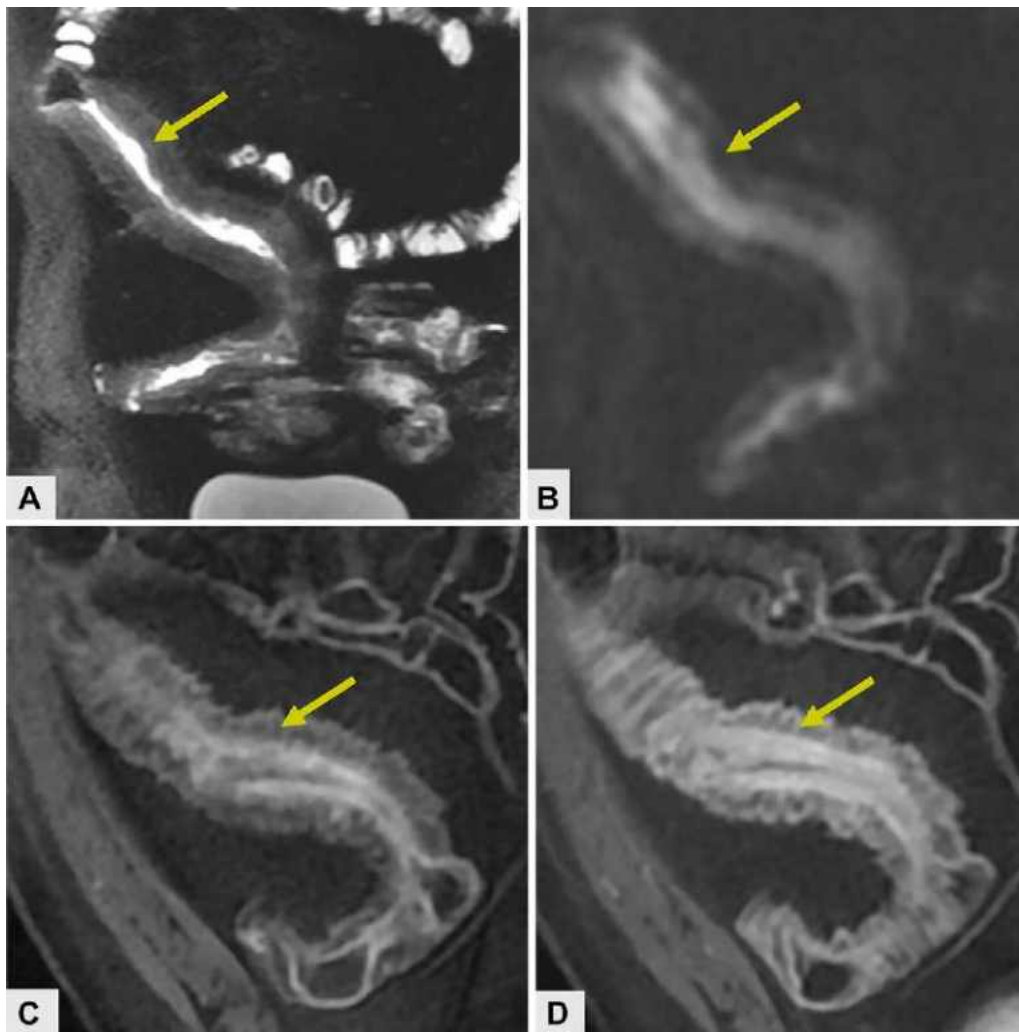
CD stricture with inflammation in a 32-year-old man. (A) Coronal T2-weighted single-shot fast spin-echo fat-saturated MRE image shows ileal luminal narrowing (arrow) with mild-to-moderate intramural edema. (B) Coronal diffusion-weighted MRE image shows restricted diffusion along the inner wall of the stricture (arrow). (C, D) Coronal contrast-enhanced fast spoiled gradient-echo fat-saturated MRE images show a layered pattern of intramural enhancement at 70 seconds (C) and 7 minutes (D), as well as enhancement gain, which is most characteristic of strictures (arrow) with high levels of inflammation, as well as fibrosis.
